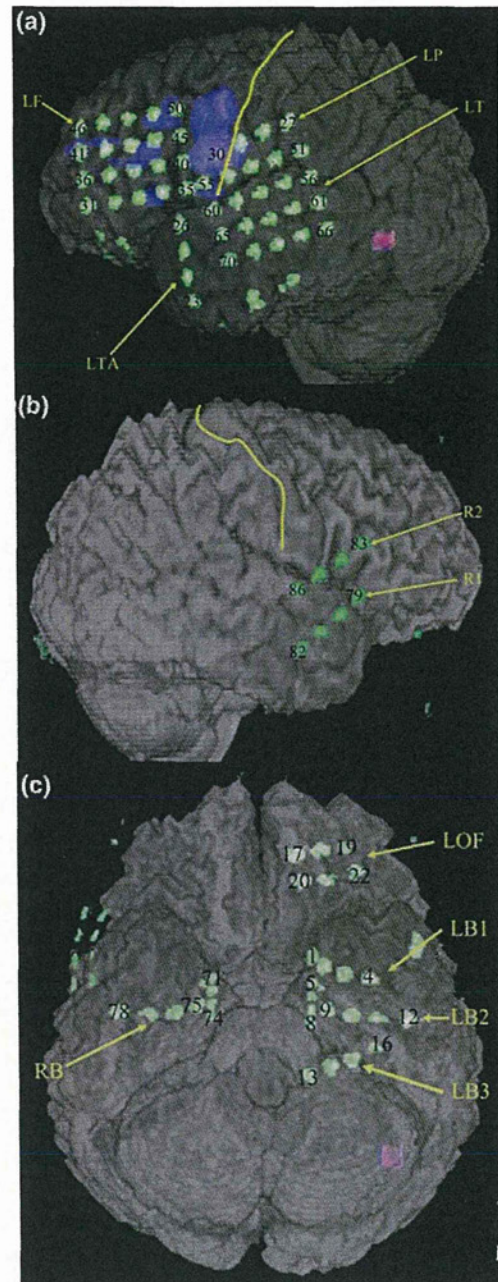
Representative 3D reconstruction from computed tomography (CT) overlaying CT and MRI images of patient (Pt.) #1. a Left side. b Right side. c Base
